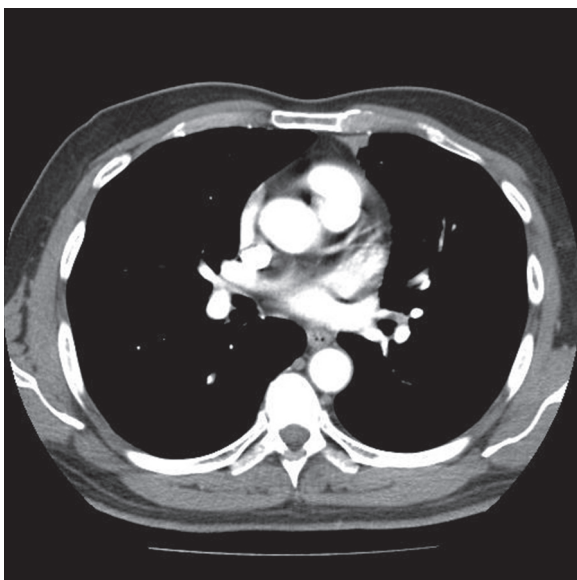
■ Axial computed tomography scan showing a single pulmonary vein trunk on the left side draining into the left atrium.
